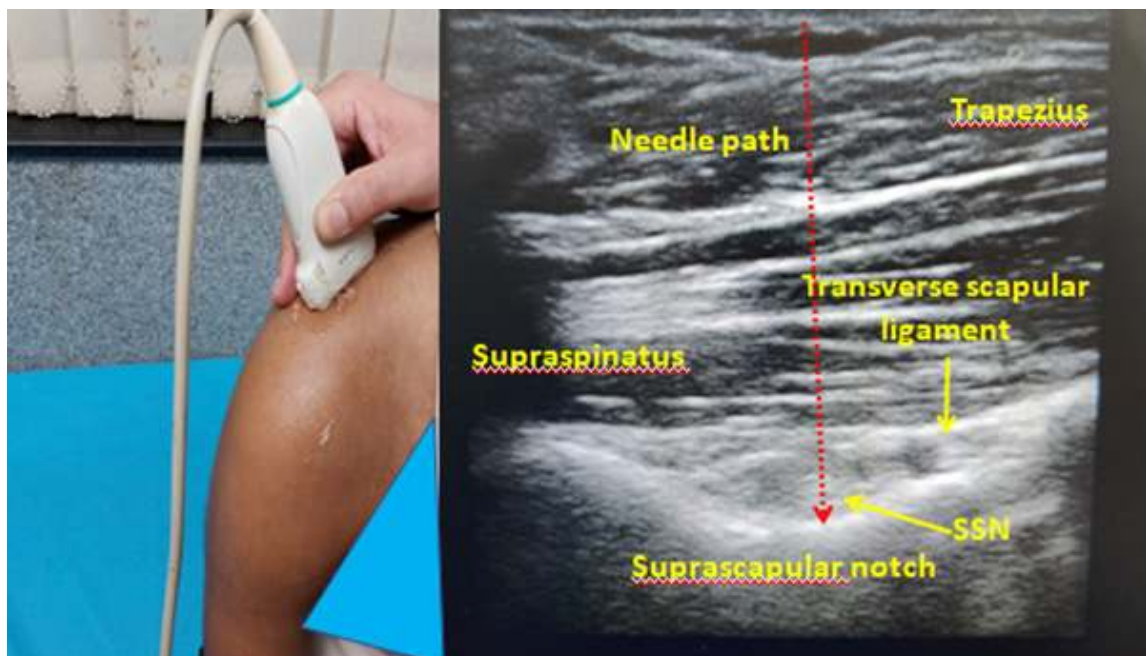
Ultrasound guided suprascapular nerve block in a patient with chronic shoulder pain
